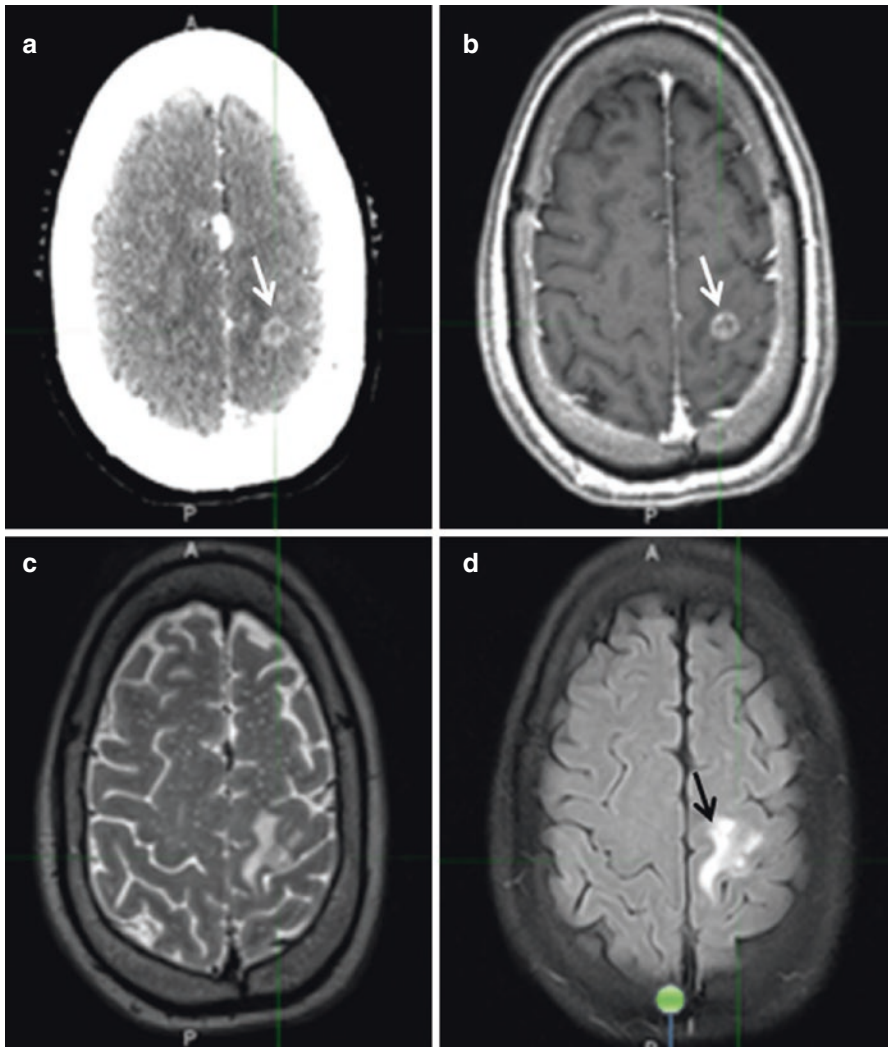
(a) Contrast-enhanced CT scan with solitary ring-enhancing lesion (*white arrow*), (b) contrast-enhanced T1-weighted MRI with solitary ring-enhancing lesion with hypointense necrotic core (*white arrow*), (c) T2-weighted MRI and (d) FLAIR images demonstrating hyperintensity extending beyond the lesion reflecting vasogenic edema (*black arrow*)
